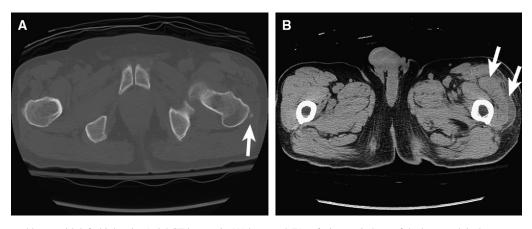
A 79-year-old man with left thigh pain. Axial CT images in (A) bone and (B) soft-tissue windows of the lower pelvis demonstrate a well-defined, 7mm, calcific density adjacent to the left greater trochanter (arrow). Surrounding low-attenuation within the soft tissues of the left hip is compatible with oedema (arrows).
